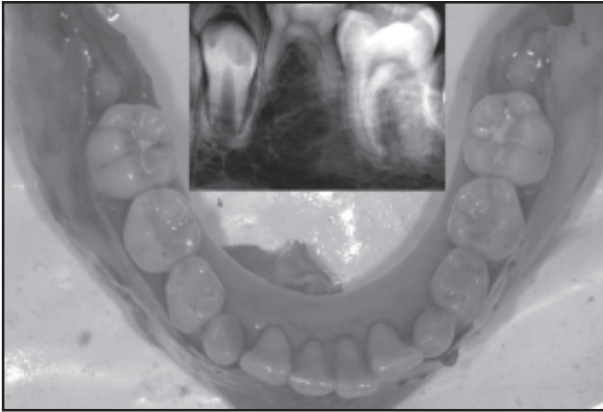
Status of the lower jaw and the radiograph of the 35 region
